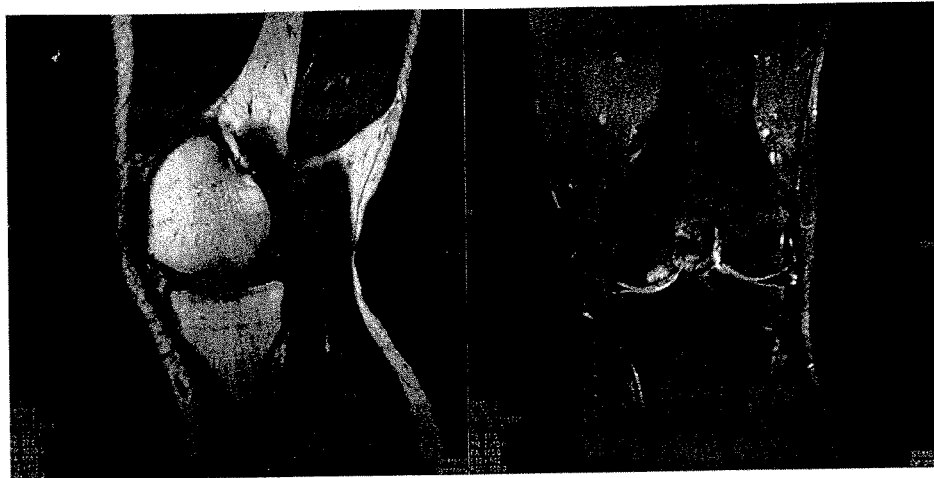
Magnetic resonance imaging results 6 months after autologous chondrocyte transplantation-collagen membrane seeding. Magnetic resonance imaging results indicate good integration and filling of the defect 6 months after the autologous chondrocyte transplantation-collagen membrane seeding procedure. Minimal edema is evident and normal at this time.
